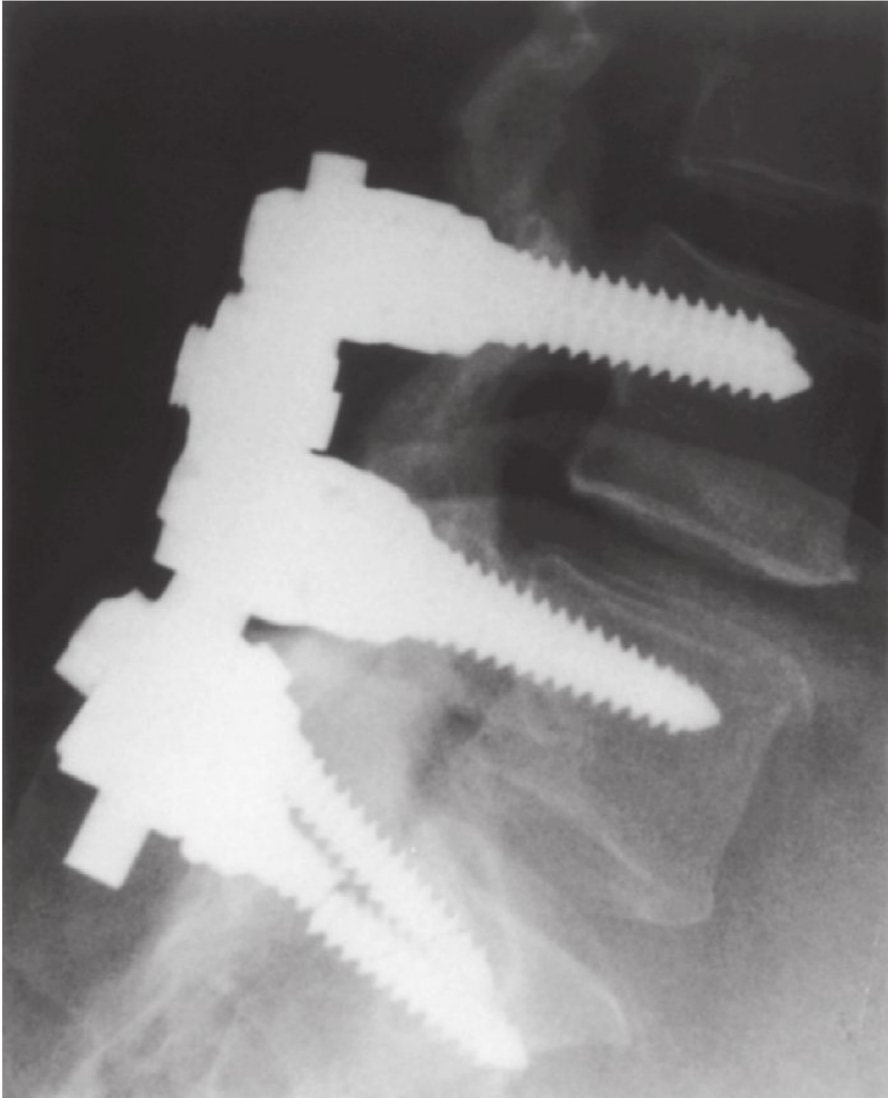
Lateral radiograph of the lumbar spine. Note that the sacral screw has broken because fusion has not occurred. Pedicle screws will eventually fail with cyclical loading if a solid arthrodesis is not obtained.
